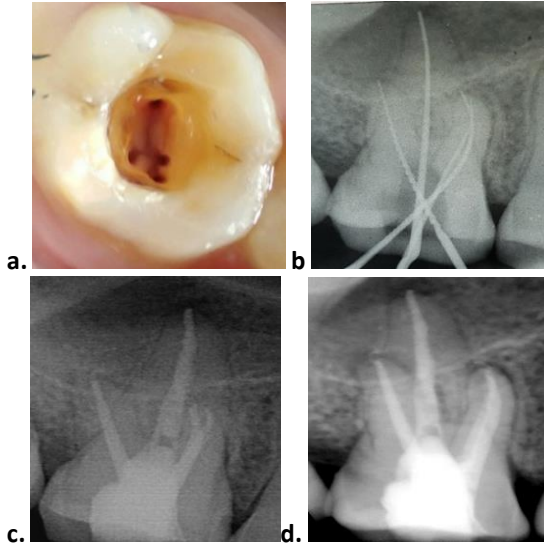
Representing type III canal configuration in the mesiobuccal root. a. Photograph of access cavity, b. Working length determination x-ray, c, and d. Post-obturation x-ray
